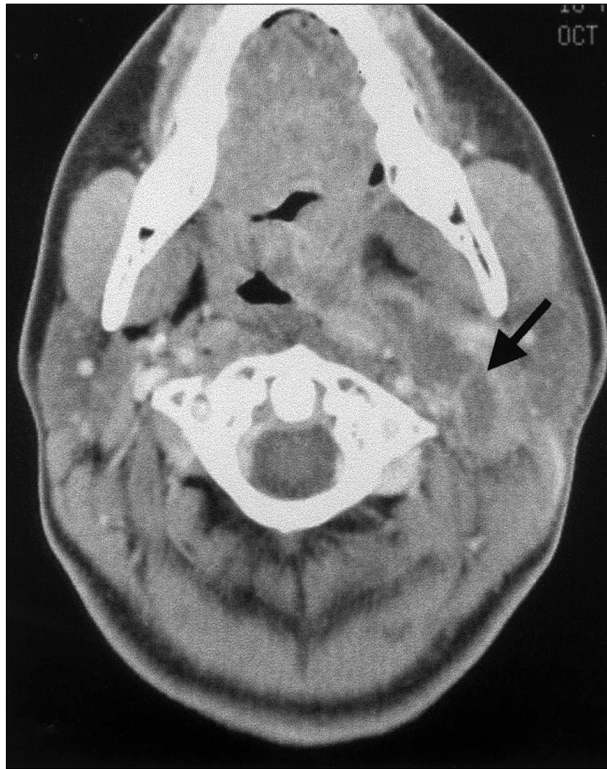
Computed tomography scan with contrast in the axial plane indicating a homogeneous, hypodense area surrounded by ring enhancement indicating an abscess involving the left parapharyngeal space.
